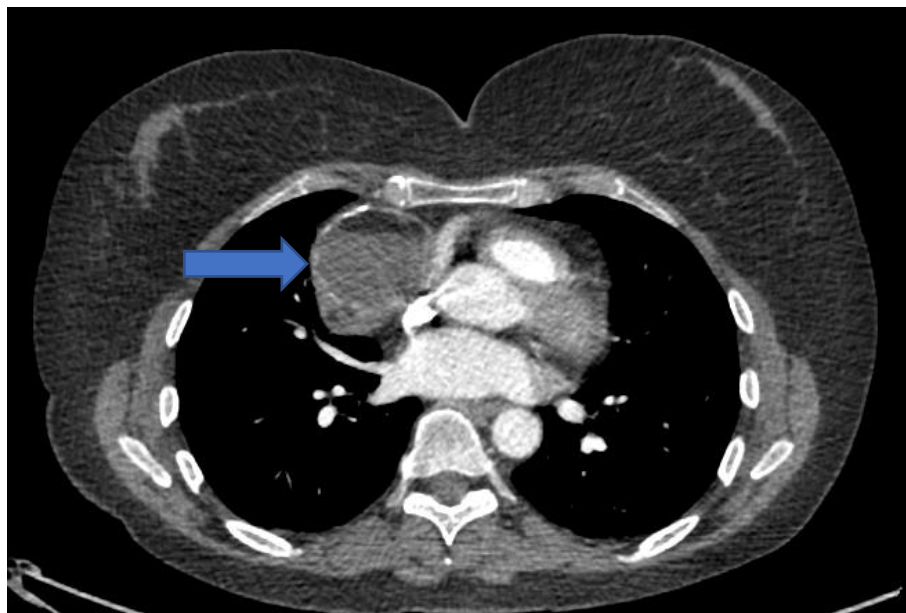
Mature cystic teratoma. CT shows a calcified right-sided anterior mediastinal mass (blue arrow).
